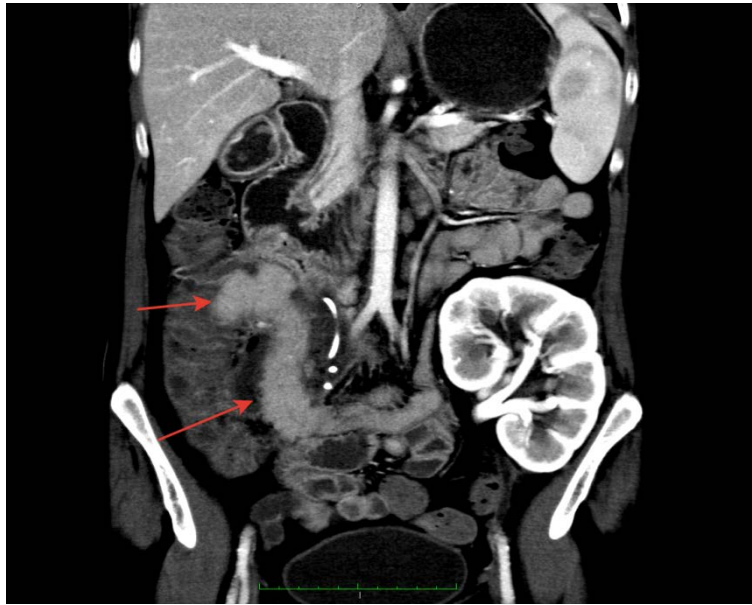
Multislice spiral computed tomogram of the abdominal cavity
